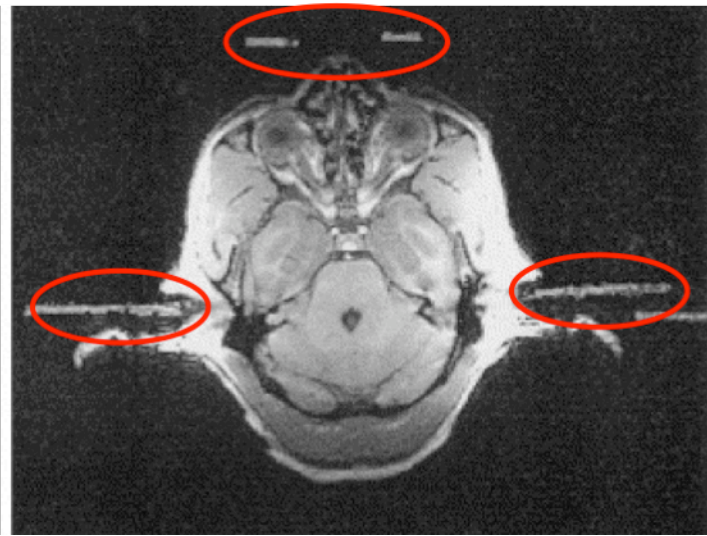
MRI with markers in ear bars and eye bars [15].
